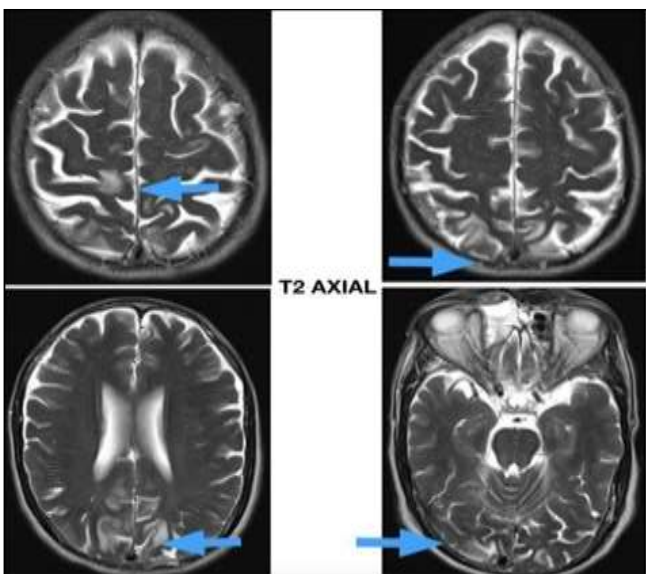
MRI brain which revealed T2/ FLAIR hyper intensities involving bilateral cortical and sub cortical regions of parieto occipital lobes and high frontal and parietal lobes in watershed regions
